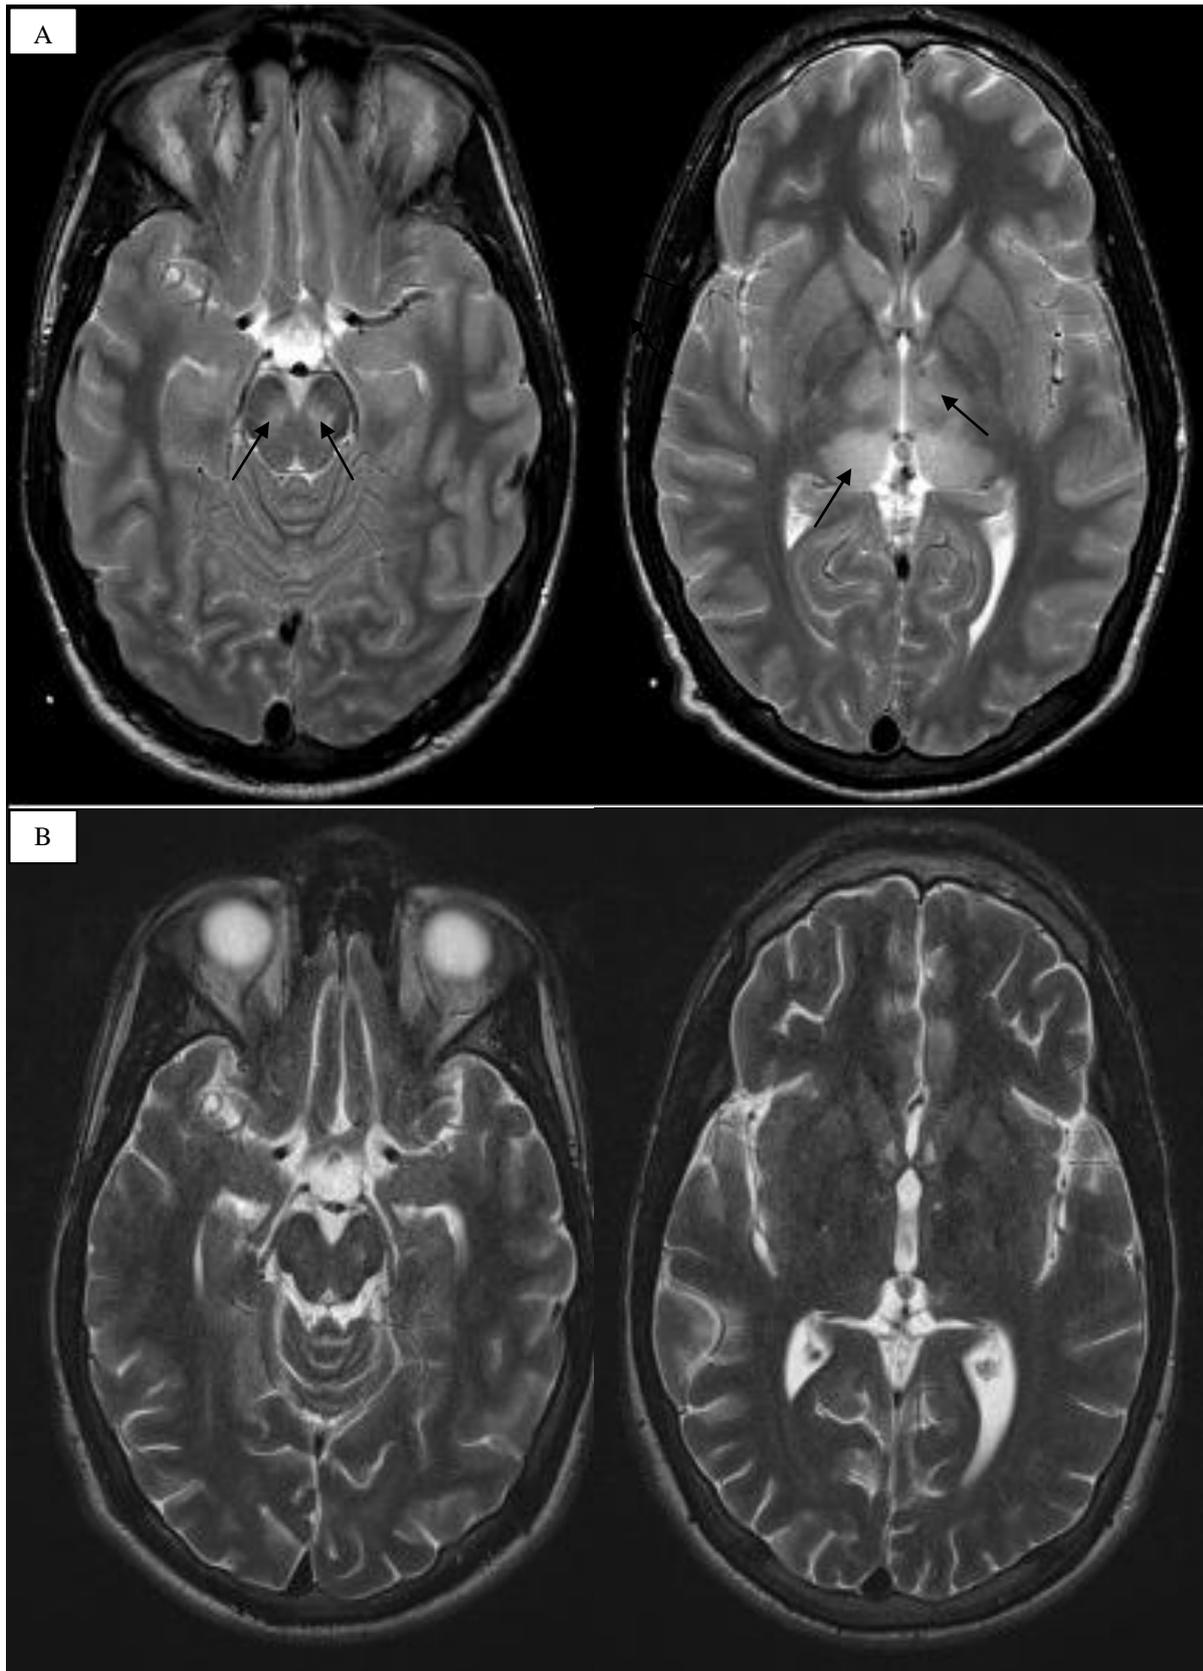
T2 sequences of cerebral MRI 15 days (A) and 5 month (B) after the onset.
